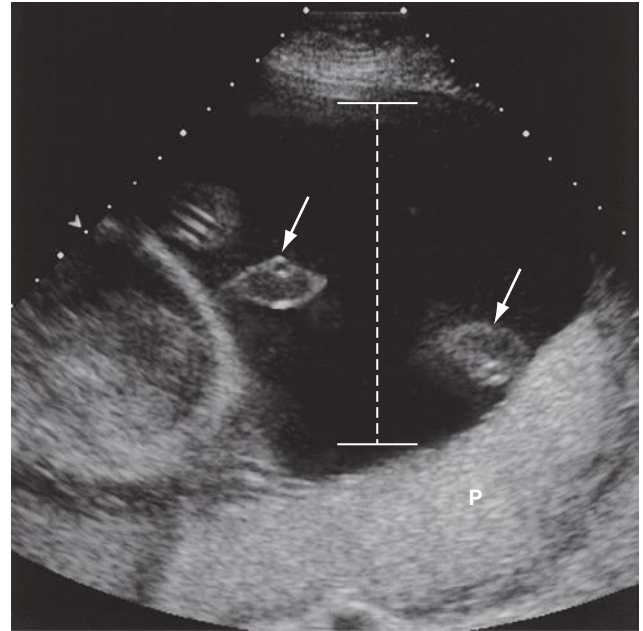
Sonogram of a pocket of amniotic fluid in a patient with hydrops fetalis and polyhydramnios. Two small segments of umbilical cord (arrows) are seen traversing the measured pocket of amniotic fluid. The placenta (P), which appears normal to prominent in this case, is, in fact, abnormally thickened.
